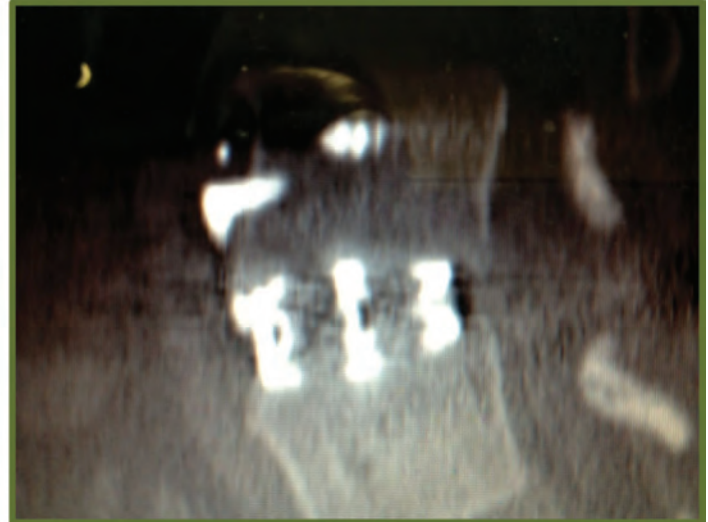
Radiographic evidence of fusion at 4 months after the cage was implanted. *Images courtesy of 4WEB, Inc.*
